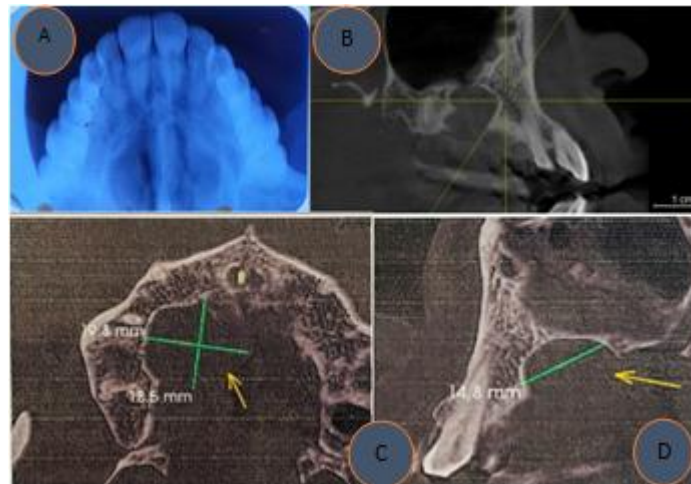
A showing occlusal radiograph Figure 2 - B, C, D reveals presence of soft tissue lesion. dimension and extension of lesion
